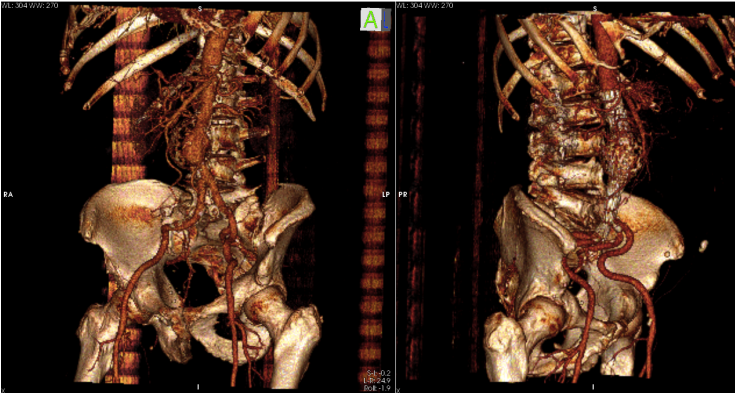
3D volume rendering of CTA series of pre- (left) and post-operative (right) study of aortic aneurysm provided by Osirix software
